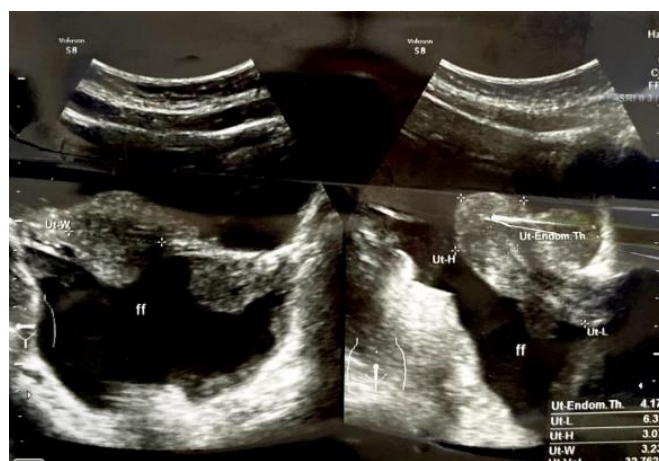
Ultrasound showed an anteflexed uterus.
